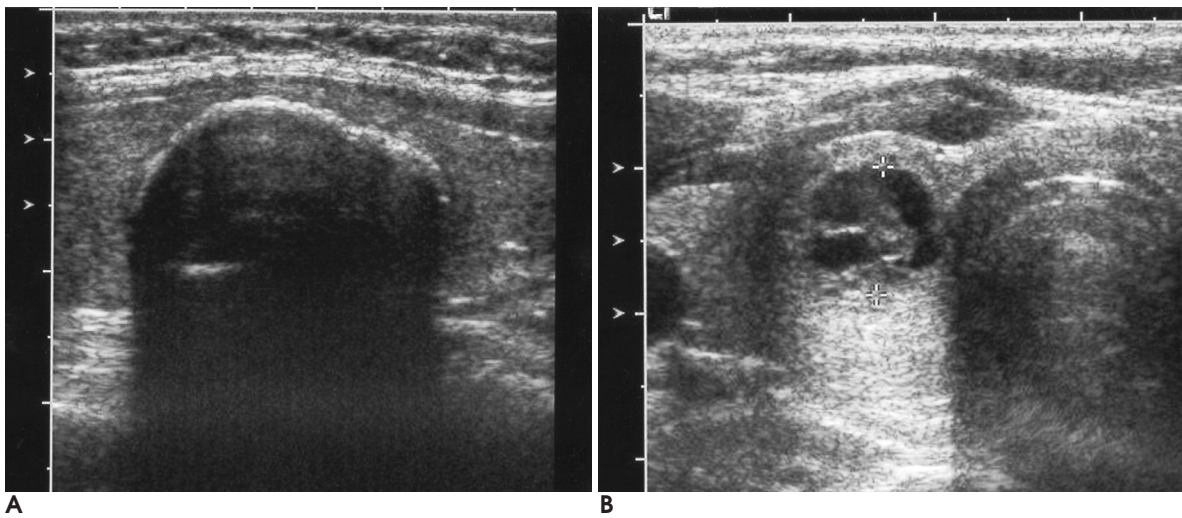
Sonographic appearance of benign looking thyroid nodules.
